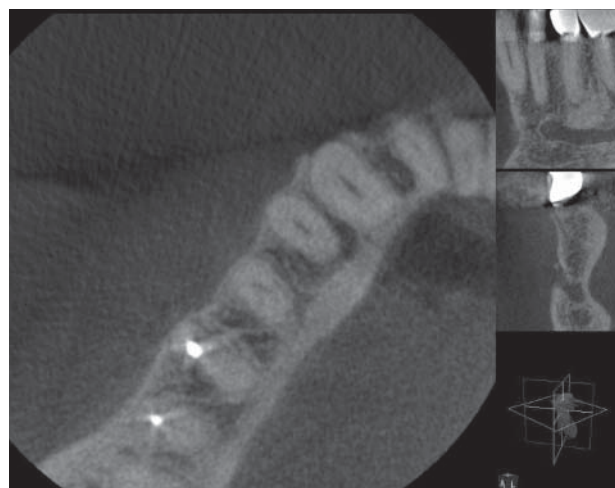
Radiograph shows tooth #30 prior to retreatment.
